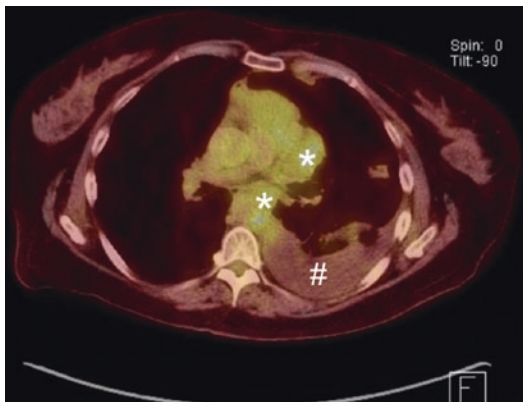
FDG-PET-CT can help distinguish tumor (*) from pleural effusion (#); however, the use of FDG-PET-CT in assessment of response to treatment has not yet been validated
